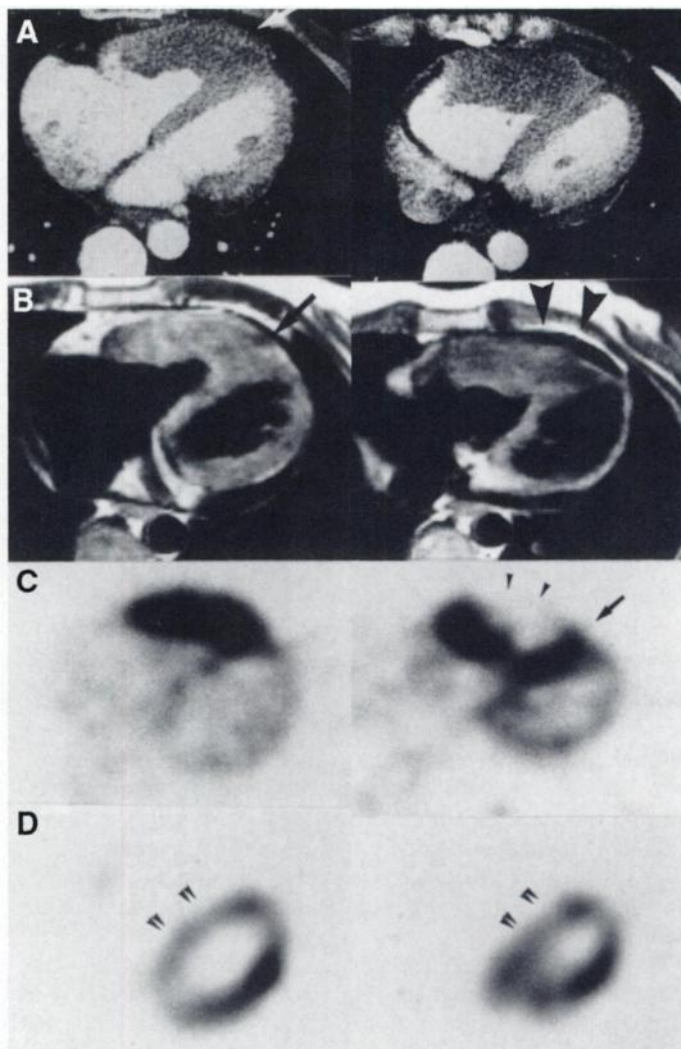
(A) EBT. Right ventricular tumor with soft-tissue density is slightly less enhanced by contrast medium than normal myocardium (white arrow). (B) MRI. It also demonstrates right ventricular tumor. Some pericardial effusion (large arrowheads) and loss of pericardial fat (large black arrow) suggest tumor invasion of pericardium. (C) Fluorine-18-FDG PET myocardial scan in fasting state shows high levels of ^{18}F -FDG accumulation in corresponding site to right ventricular tumor and also in interventricular septum (small black arrow). Fluorine-18-FDG uptake was decreased in part of right ventricular tumor (small arrowheads). (D) Technetium-99m-sestamibi myocardial SPECT. Mild perfusion defects are demonstrated in anteroseptal and septal myocardial regions (double arrowheads).
